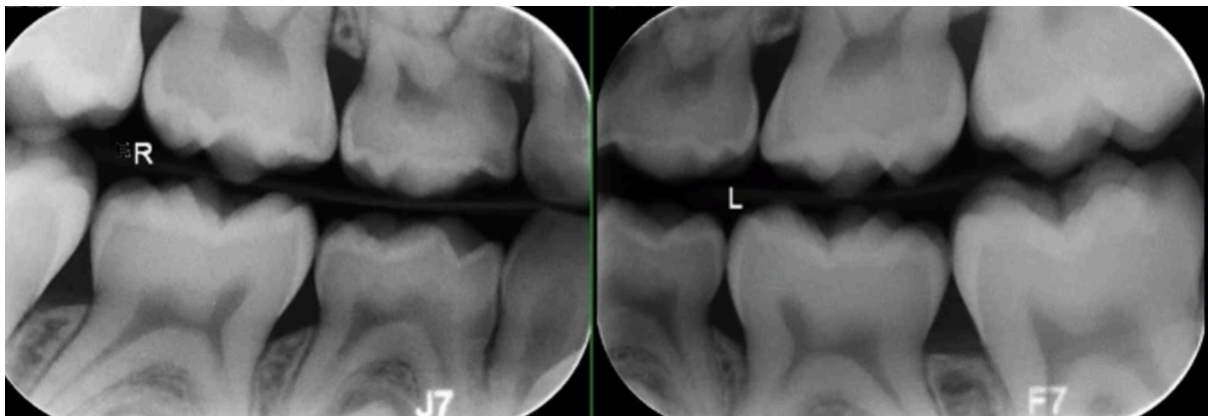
Bitewing radiograph showing a hypomineralized lower left first permanent molar with radiolucent areas and post-eruptive enamel loss, typical of MIH (Humphreys et al., 2021).
